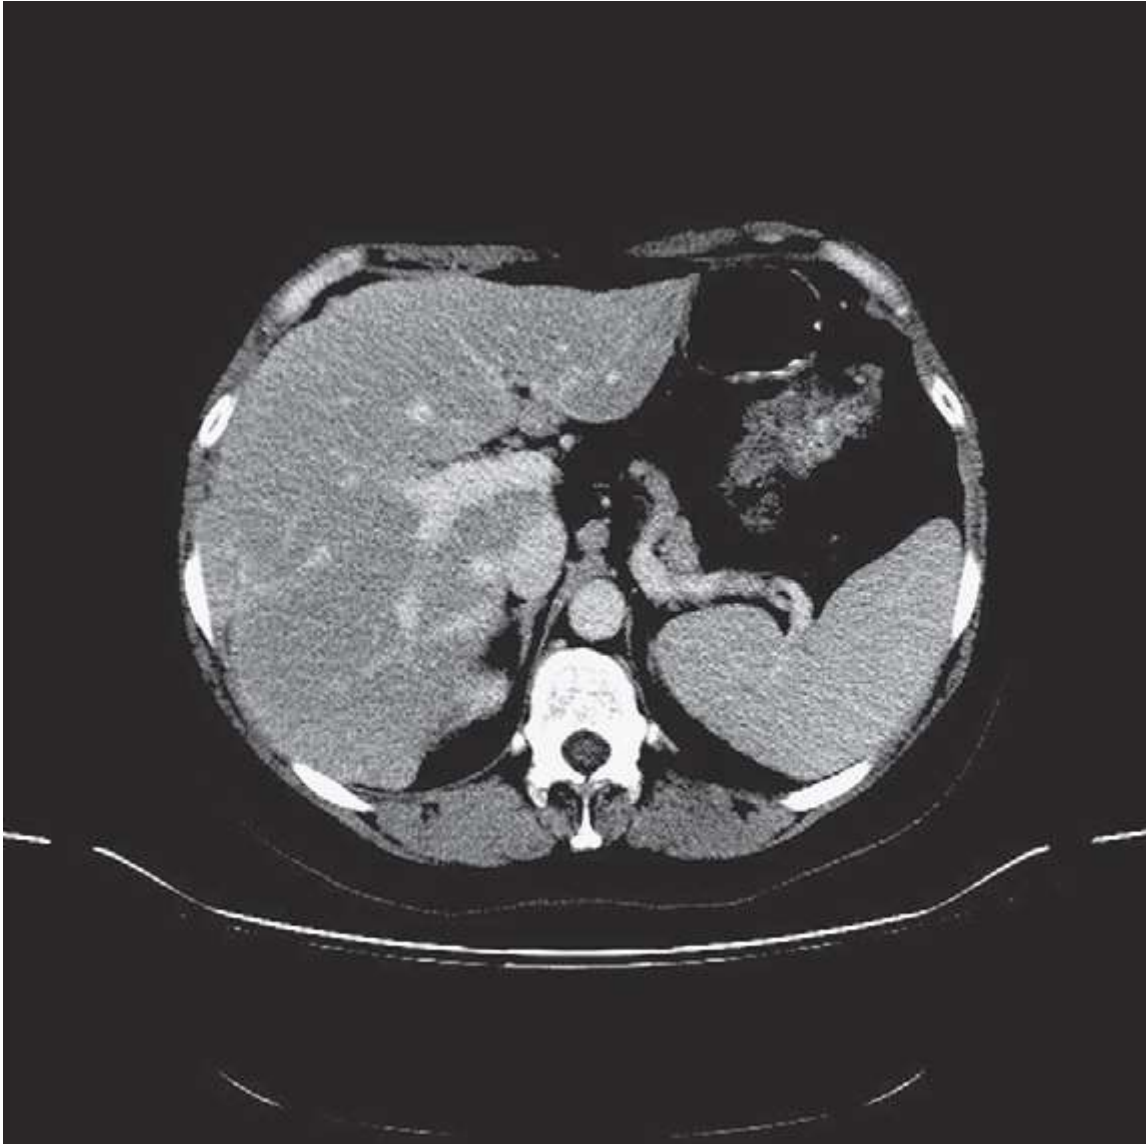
A: Three-phase computed tomography (CT) of the liver following a bolus injection of intravenous contrast, demonstrating the arterial circulation.
